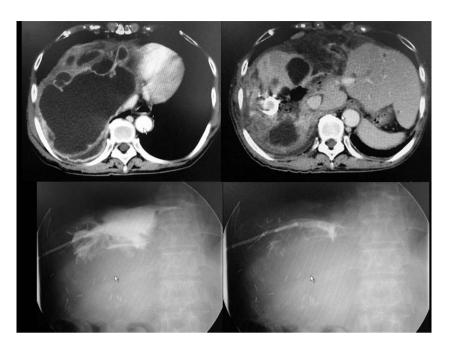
CT findings and fistulography of massive right subphrenic fluid collection. Upper left: abdominal CT taken on postoperative day 10 when sudden abdominal fullness and resultant severe anorexia developed. Upper right: abdominal CT taken 3 days after percutaneous drainage for right subphrenic massive fluid collection. Lower left: fistulography via percutaneous drainage performed for measuring the volume of cavity. Lower right: fistulography after complete aspiration of contrast media. Abdominal CT revealed massive fluid collection in the right subphrenic space 10 days after surgery (upper left). Massive fluid collection was eradicated by percutaneous drainage (upper right). DWL for massive fluid collection via percutaneous drainage was performed under fluoroscopic guidance. First, fistulography via drainage tube was performed for measuring the volume of cavity (lower left). After complete aspiration of contrast media used volume measuring (lower right), distilled water was injected into the cavity with the volume confirmed by preceded fistulography.
